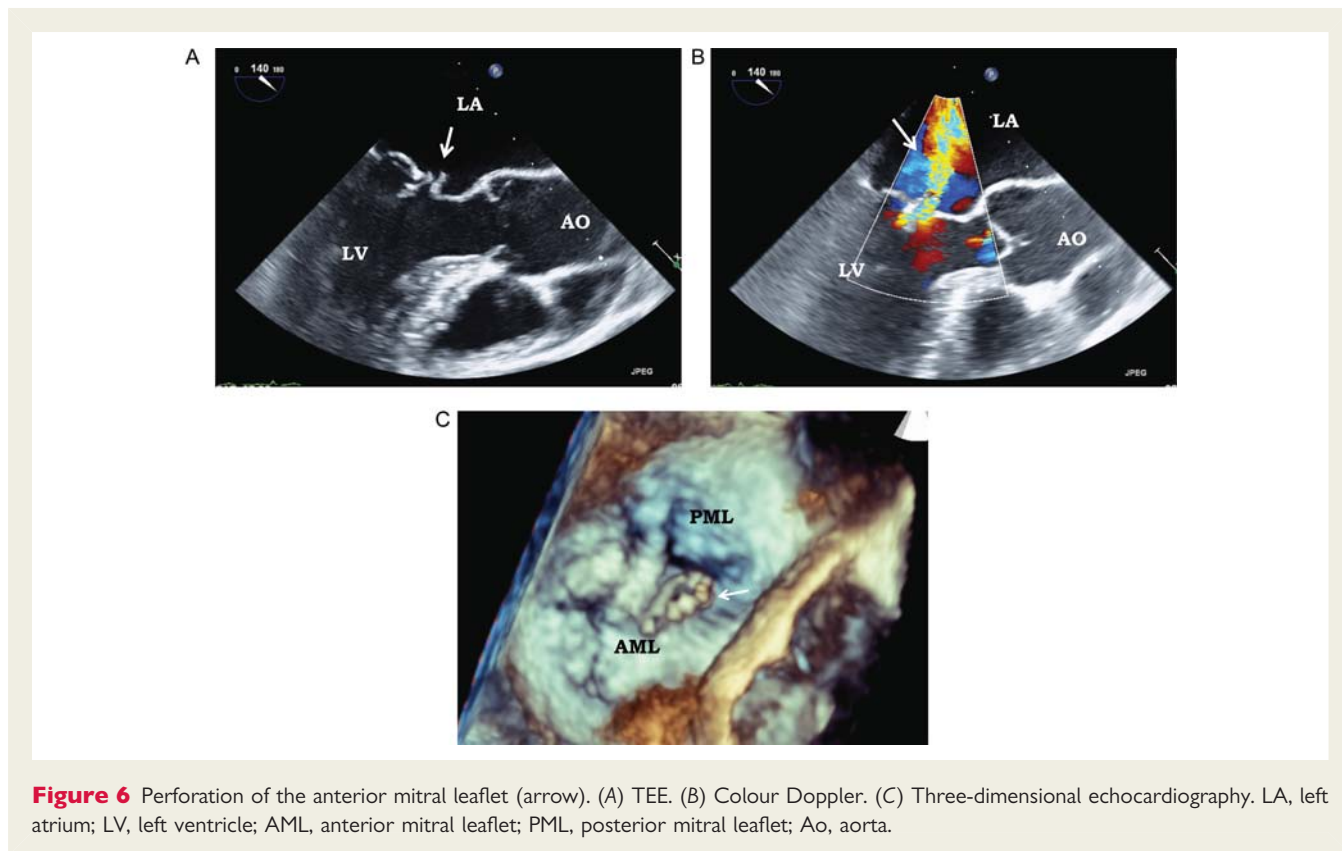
Perforation of the anterior mitral leaflet (arrow). (A) TEE. (B) Colour Doppler. (C) Three-dimensional echocardiography. LA, left atrium; LV, left ventricle; AML, anterior mitral leaflet; PML, posterior mitral leaflet; Ao, aorta.
